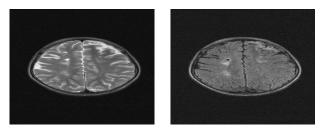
MRI brain axial T2WS & FLAIR sequences. respectively)⁴⁻⁶.
